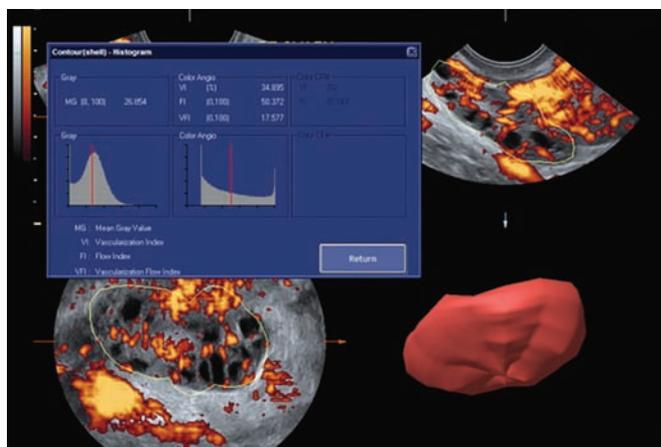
Three-dimensional ultrasound with VOCAL and volume histogram for quantitative evaluation of the global ovarian stromal flow
